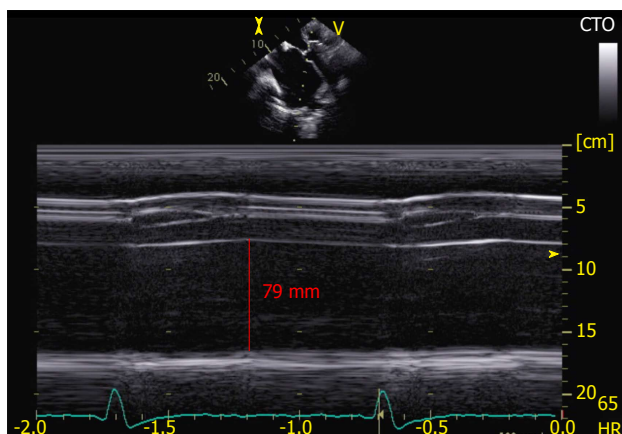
Parasternal long axis view in M-mode at the level of the aortic valve and left atrium. The dilated diameter of the left atrium (79 mm) is shown.
